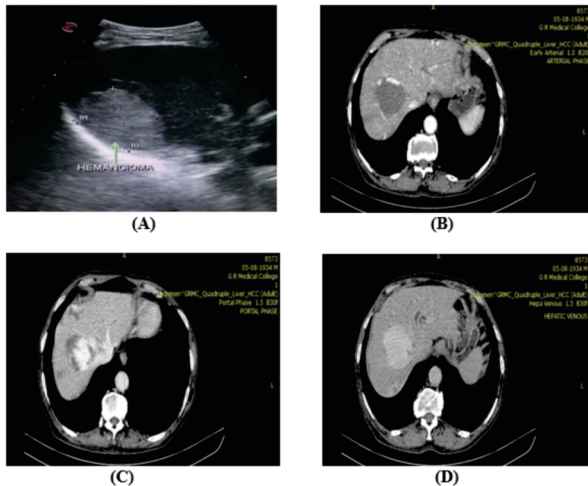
A. USG shows typically well-defined hyperechoic lesions. B. CT Arterial Phase: typically show discontinuous, nodular, peripheral enhancement and progressive centripetal filling C & D)
